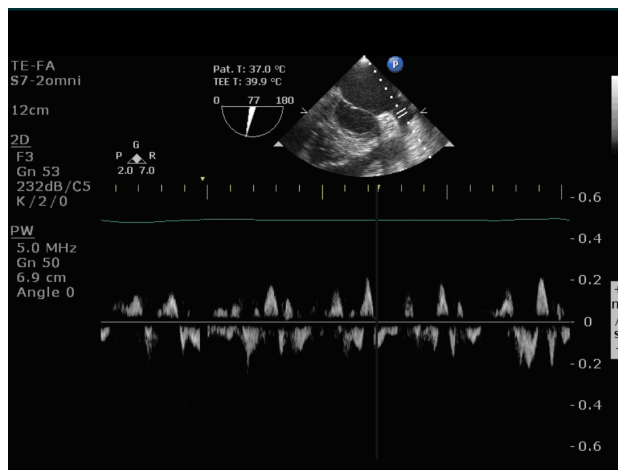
Cardiac ultrasound – intra-auricular slow blood flow.
